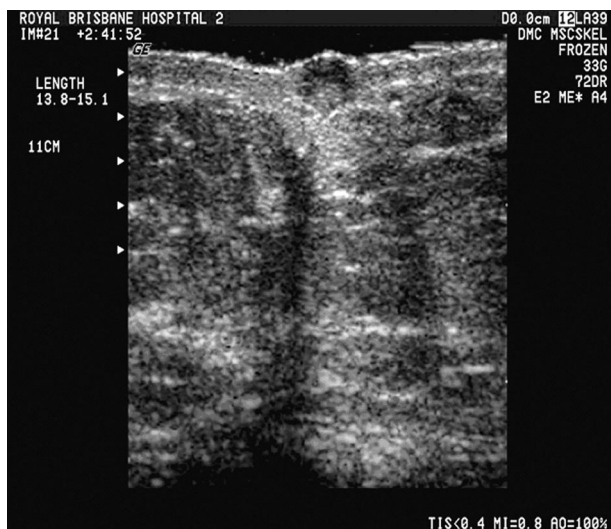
Ultrasound appearance of surgical scar fibrosis within the dermal and epidermal layers.
